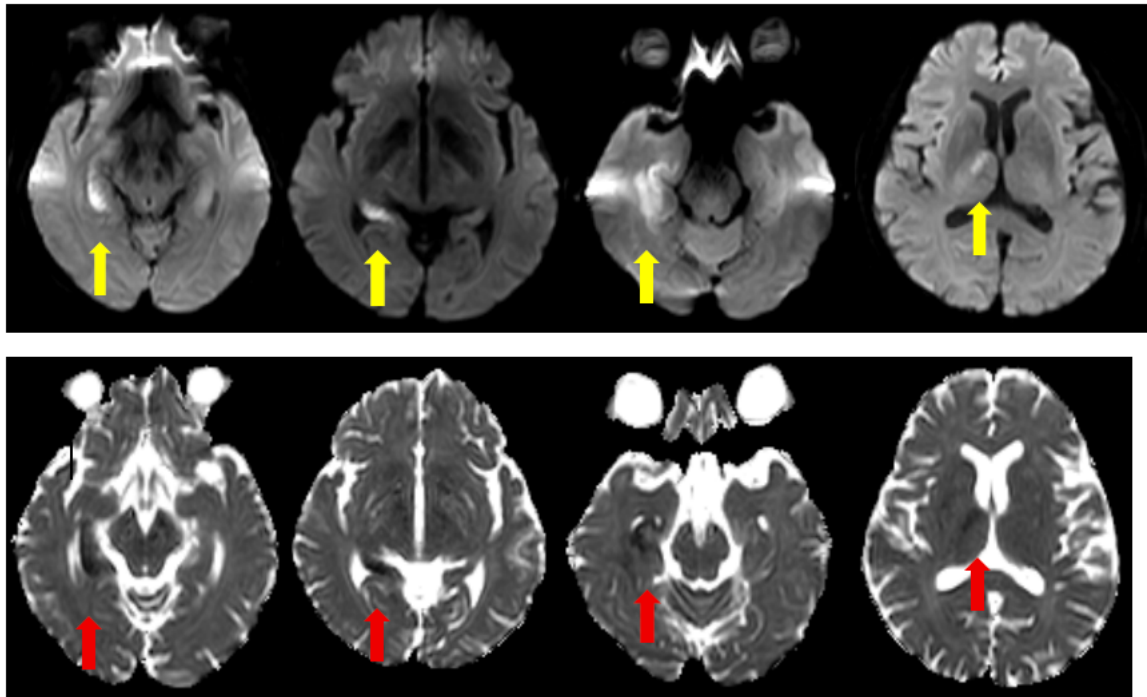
Areas of acute infarctions evidenced by hyperintense signals on DWI (green arrows) and hypointense signals on ADC (red arrows)
